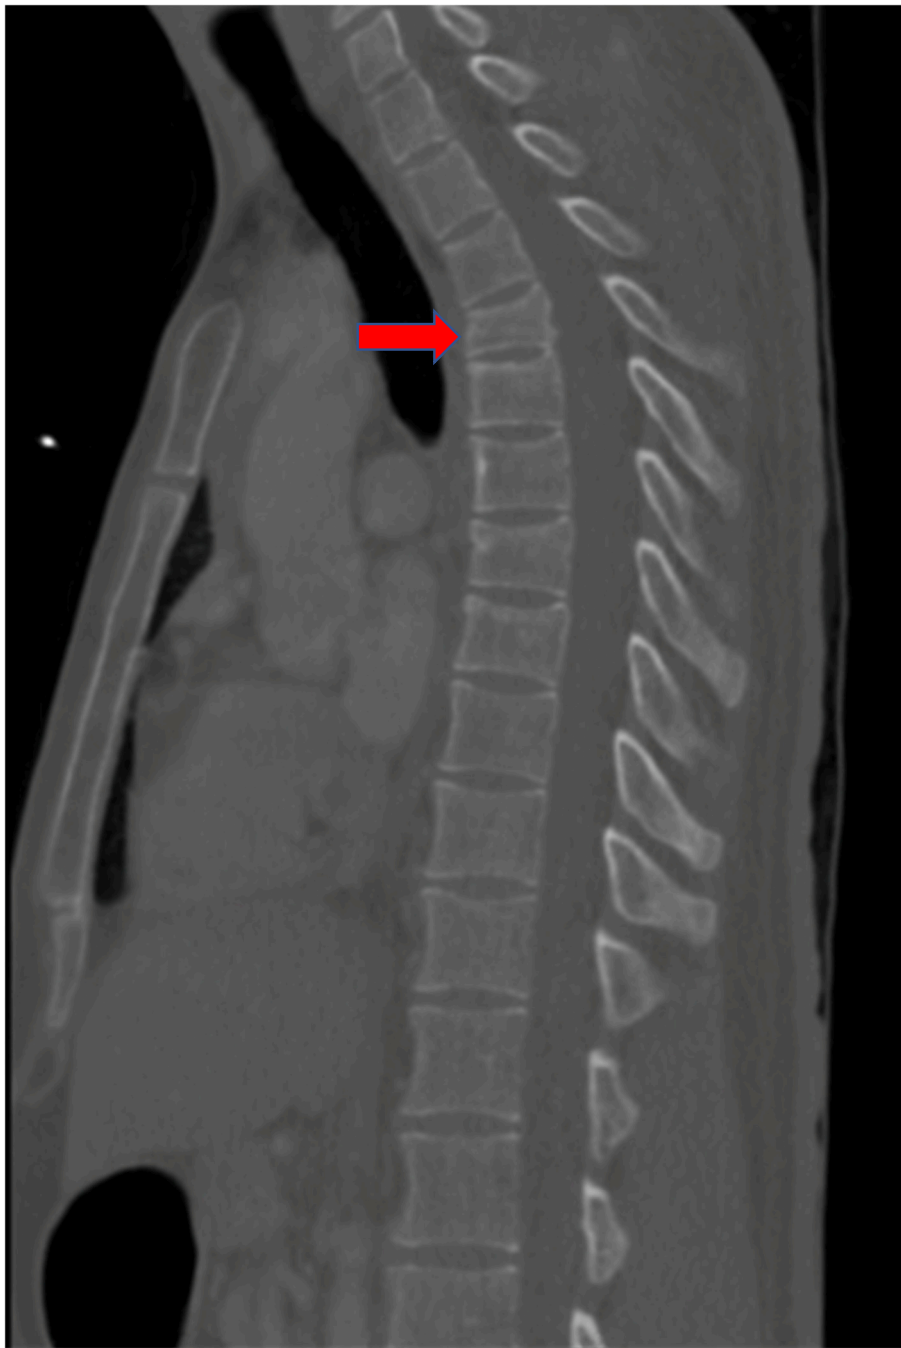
CT sagittal image (Bone Window) of the Thoracic Spine Demonstrating the most significant thoracic spine fracture T4 marked by the red arrow. (For interpretation of the references to colour in this figure legend, the reader is referred to the web version of this article.)
